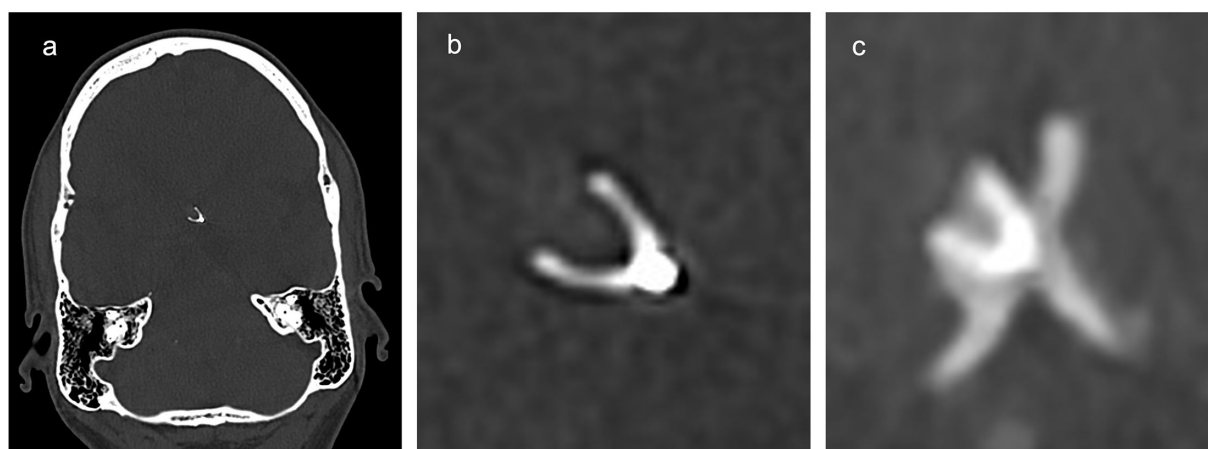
(a) Visualization of the contour device on non-contrast photon-counting CT (bone window). (b) Magnified view of (a) highlighting the device. (c) Photon-counting CT angiography demonstrating near artifact-free visualization of the contour device.
